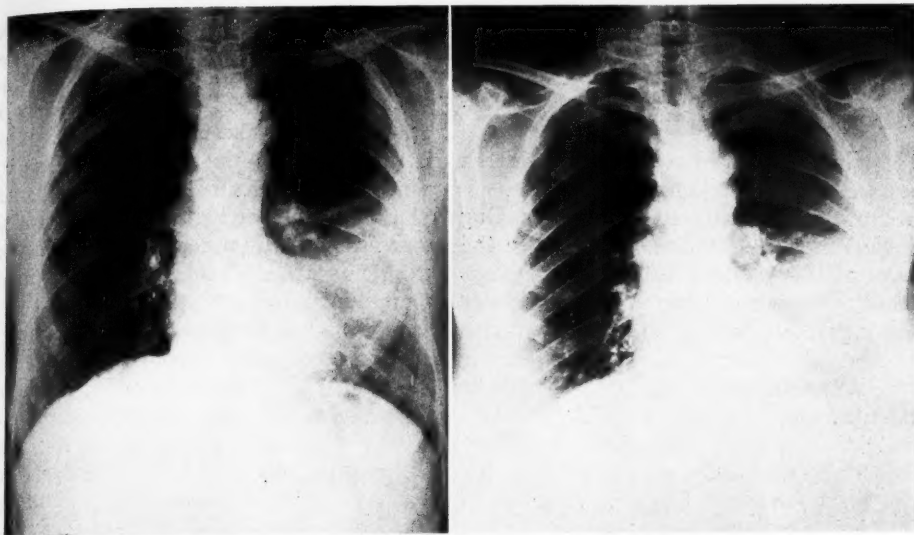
The shadow of the heel of the anode of a line focus tube or of a long cone may be cast on the film in such a way as to be confusing. Figure 8-A (left) shows a routine radiograph of a patient with pathology in the left lung and with clear costophrenic sulci. Figure 8-B (right) shows the same patient at the same time, but with the shadow of a long cone falling on the lower portion of the film. In some cases an erroneous diagnosis of fluid in the costophrenic sulci might be made.
